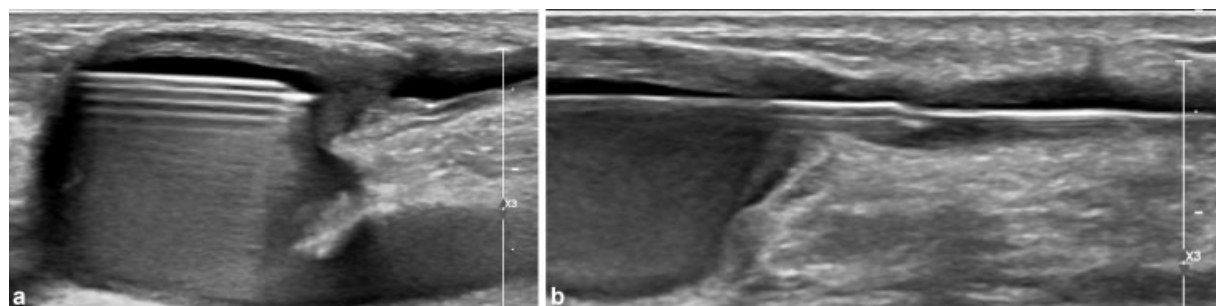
(a and b) Ultrasound-guided sharp needle recanalization using 21G needle and wire.
